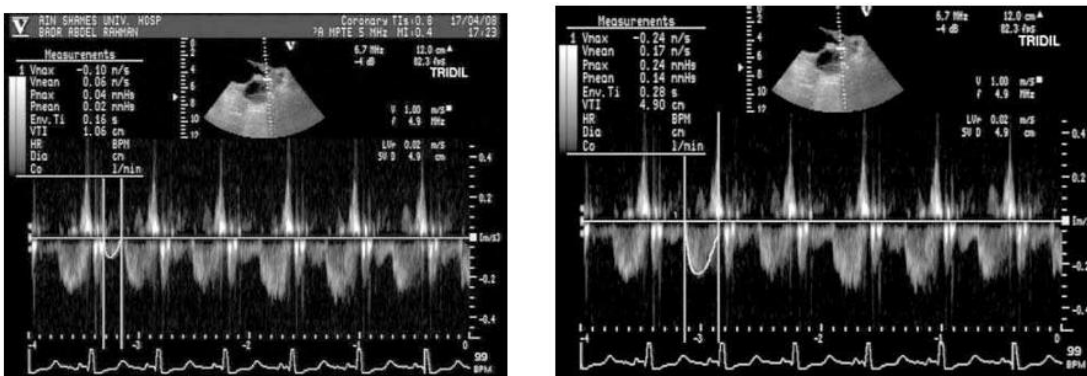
Case number 7; Doppler parameters after nitroglycerin.
